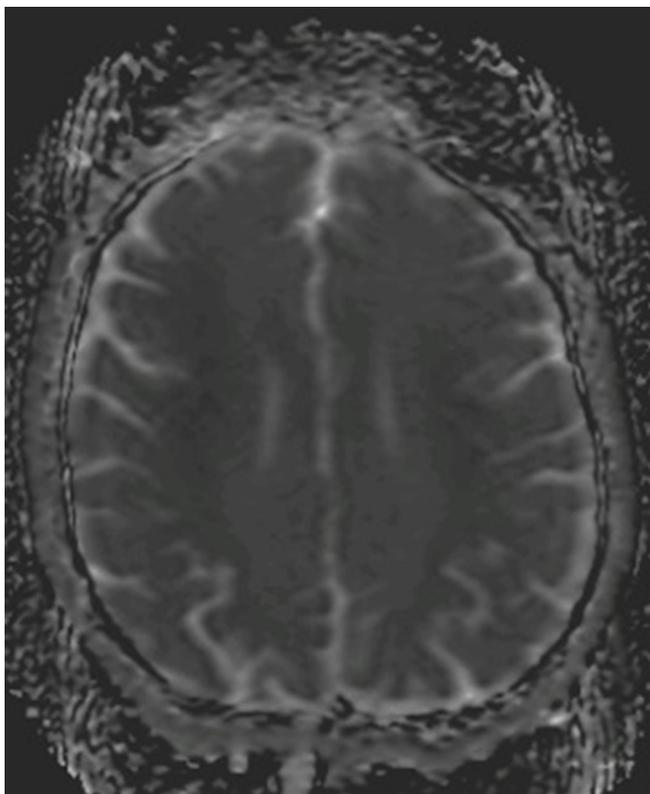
MRI brain, apparent diffusion coefficient sequence, axial section showing signal drop out in the regions corresponding to hyperintense signals on diffusion weighted imaging.
